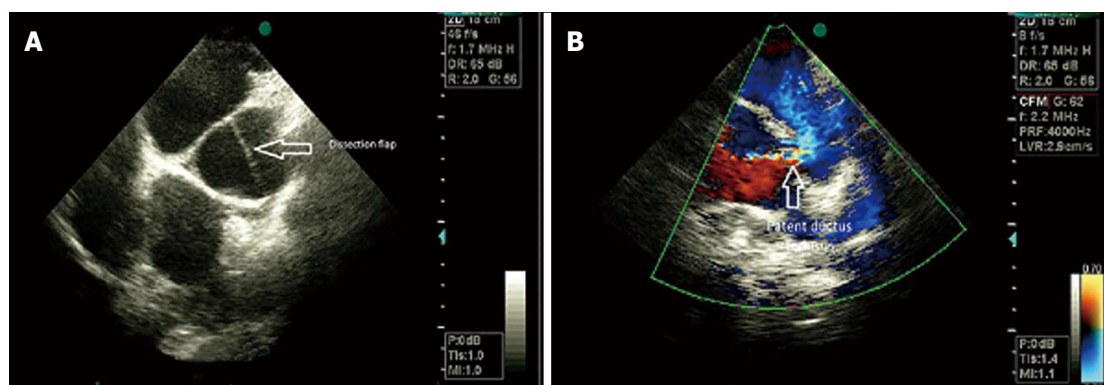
Echocardiographic views of pulmonary dissection (A) and patent ductus arteriosus (B).
